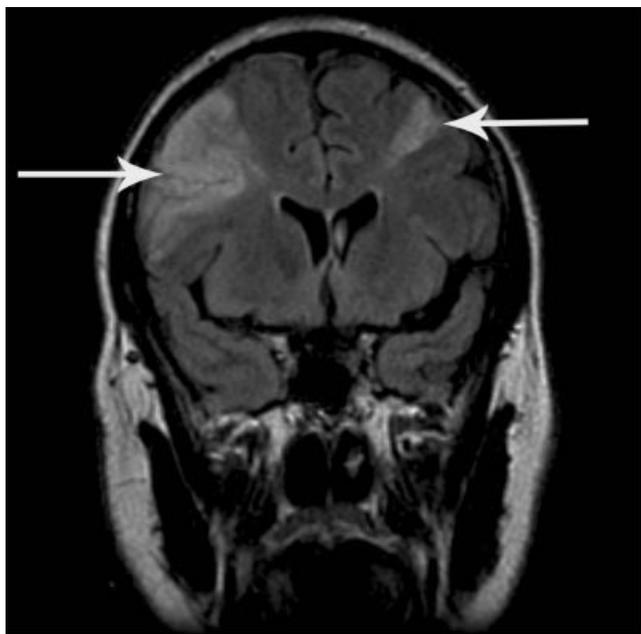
Multiple areas of cerebral infarction on FLAIR MR imaging.
